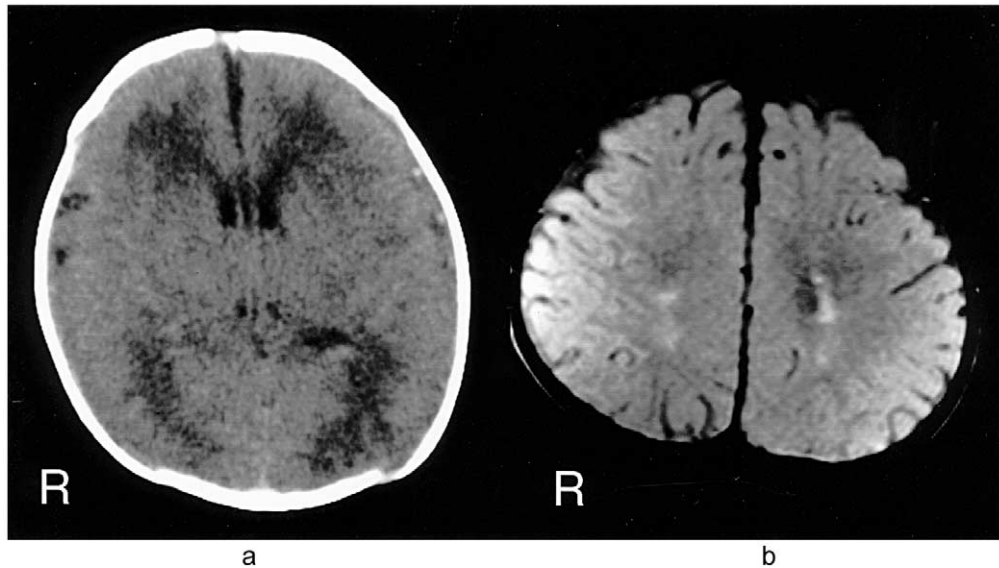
CT and MRI findings in case 2. (a) CT on the eighth day of life. Widespread low densities in the white matter and occipital lobes were recognized. (b) A proton density image on MRI at 1 year of age demonstrated abnormal high signals in the bilateral parietal regions.
